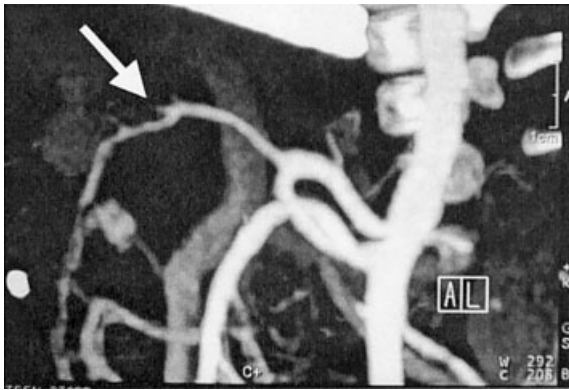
CT angiography shows complete occlusion of the hepatic artery (white arrow; \hat{u}) at the anastomosis.
